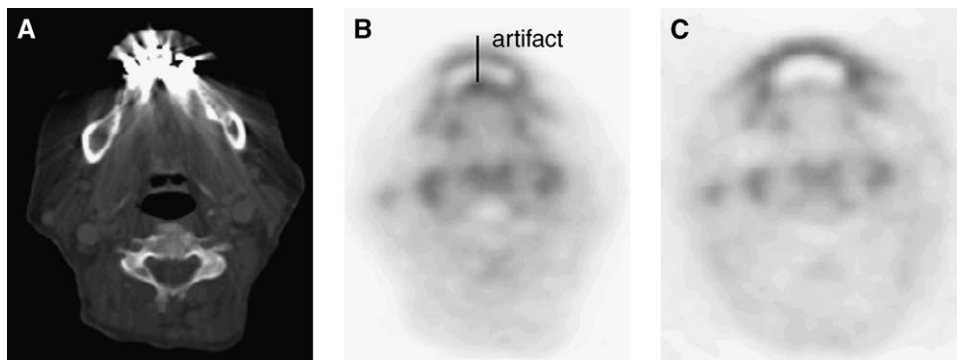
Diffuse FDG uptake in the vicinity of dental implants on corrected FDG-PET/CT images of the head and neck (B) correlates with CT artifacts (A) and is not present in the uncorrected emission images (C).
